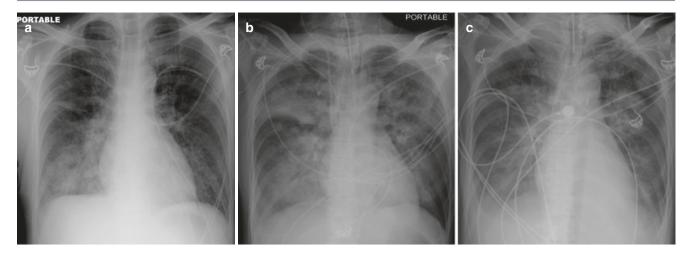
ARDS vs hydrostatic pulmonary edema. (a) AP chest radiograph in a patient with pneumonia demonstrates right midand lower zone consolidation (b) rapidly progressing to bilateral extensive asymmetrical central consolidation with air bronchograms representing an exudative phase of ARDS. (c) AP chest
